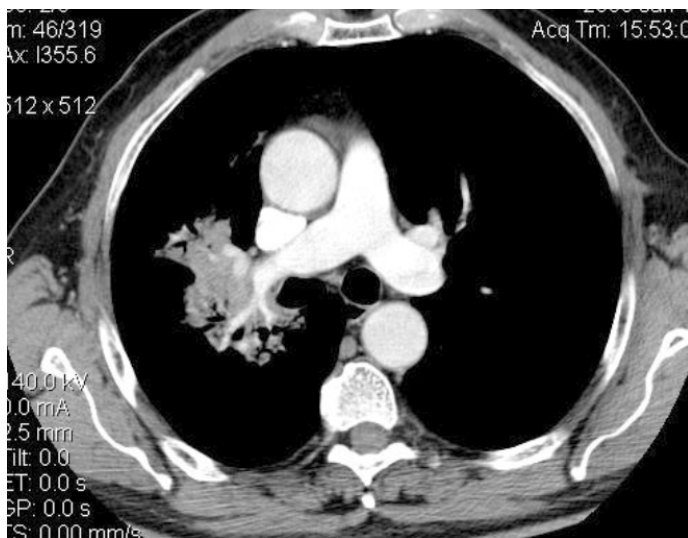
Contrast enhanced CT scan: stenosis of the right pulmonary artery at the level of the neoplasm
